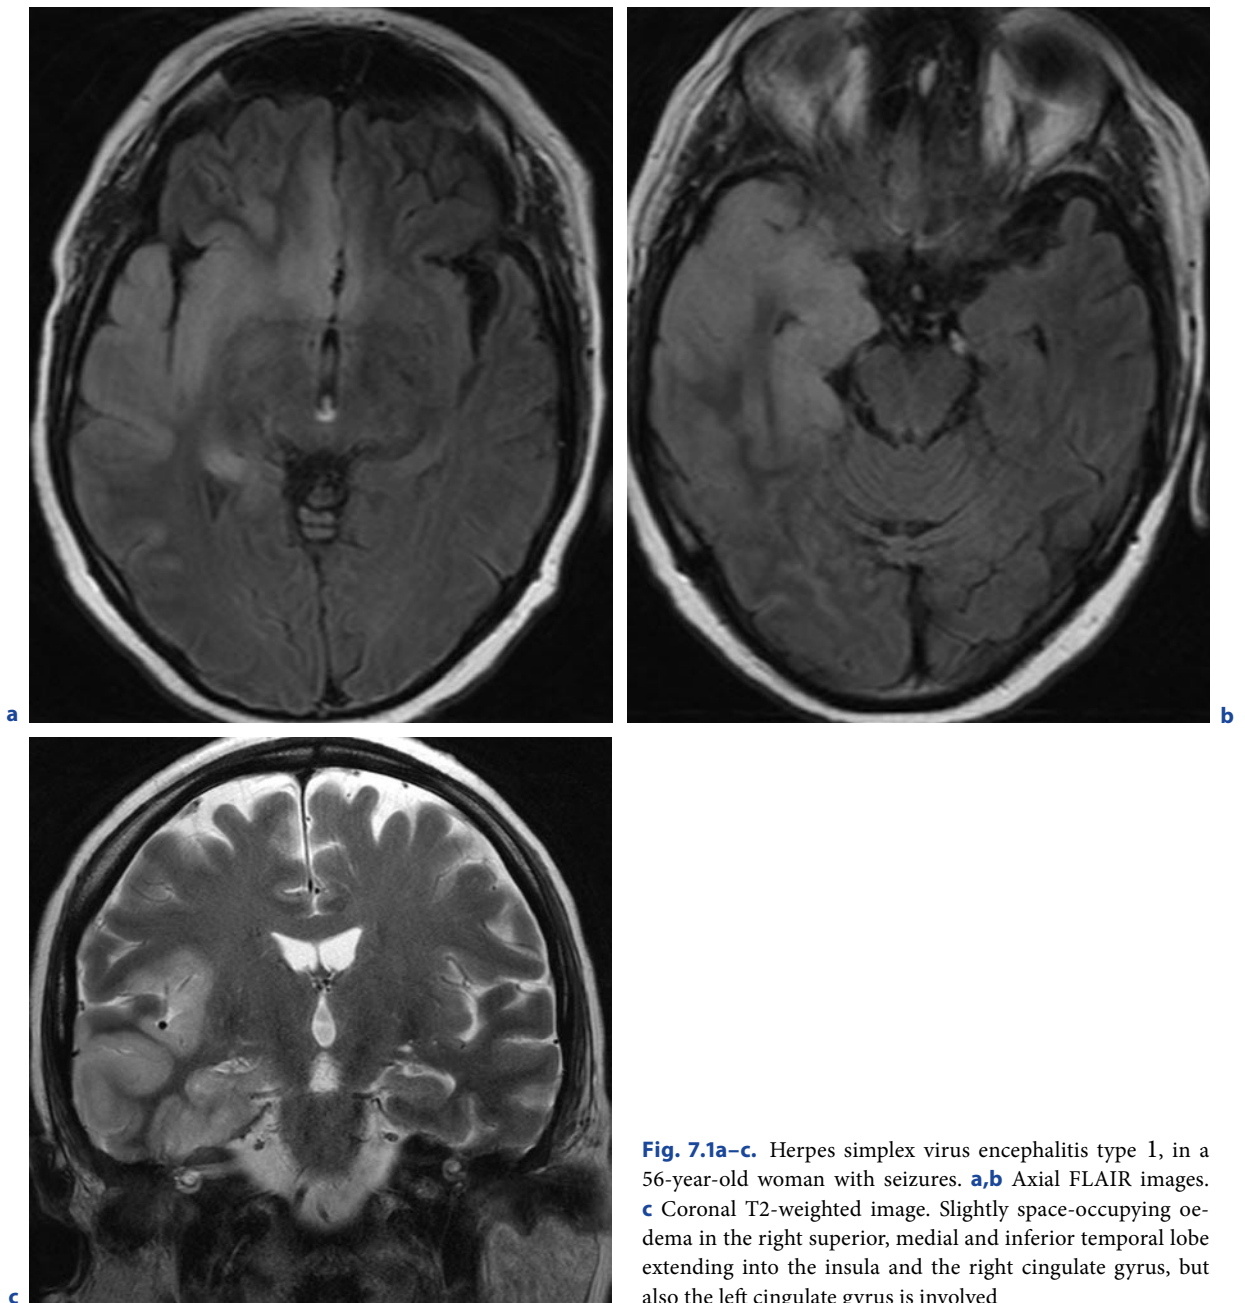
Herpes simplex virus encephalitis type 1, in a 56-year-old woman with seizures. a,b Axial FLAIR images. c Coronal T2-weighted image. Slightly space-occupying oedema in the right superior, medial and inferior temporal lobe extending into the insula and the right cingulate gyrus, but also the left cingulate gyrus is involved
